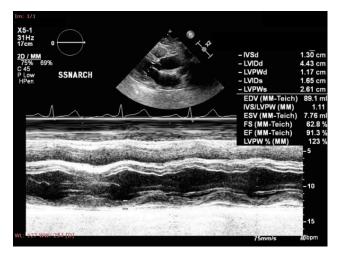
M-Mode Echocardiography of the same patient showing cardiac chamber and wall measurements. Prepared by the authors. Courtesy of the Pediatric Clinical Hospital Sibiu, Lucian Blaga University of Sibiu.
